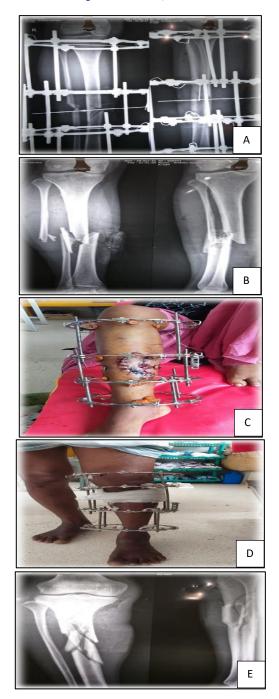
(A) Post-operative X-ray, (B) pre-operative X-ray, (C & D) post-operative pictures; and (E) preoperative X-ray.
